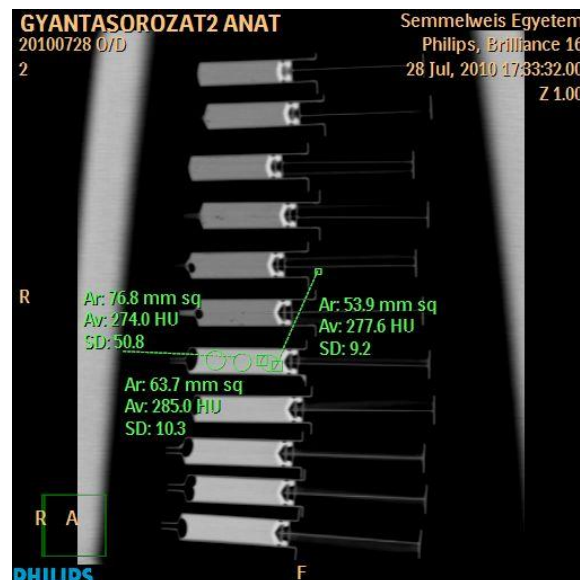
Dilution series with the different contrast materials to check the homogeneity, reproducibility and enhancement of CT density (Source: author's own work. CT scan was done by Dr. Ibolyka Dudás)
